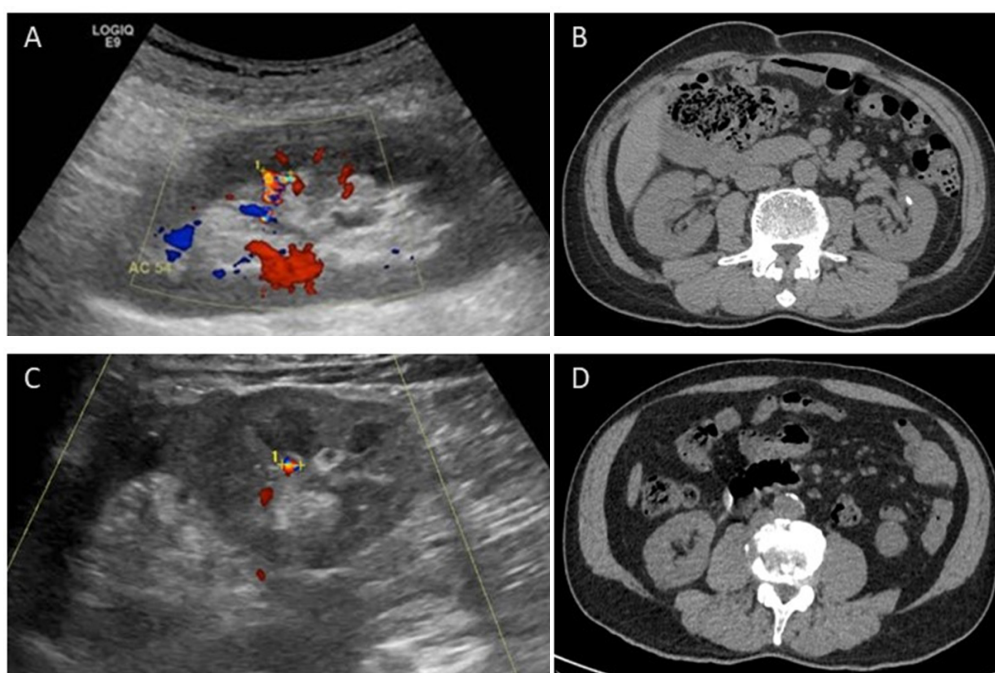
A 51-year-old man with an example of a positive result from the predictive model of nephrolithiasis (A and B). CDUS image (A) shows a TA in the mid pole of the left kidney at the junctional line, with a size of 6.6 mm and a long tail of the TA. The total score of this TA is 3, positive. The unenhanced axial CT image (B) obtained on the same day shows renal stones at the mid pole of the left kidney. In contrast, a 47-year-old woman with an example of a negative result from the predictive model (C and D). The CDUS image (C) shows a TA in the lower pole of the right kidney at the junctional line, with a 4.0 mm size. No demonstrable posterior shadow or long tail of the TA was noted. The total score of this TA is 1, representing a negative result. The unenhanced axial CT image (D) obtained on the same day shows no calculus.
